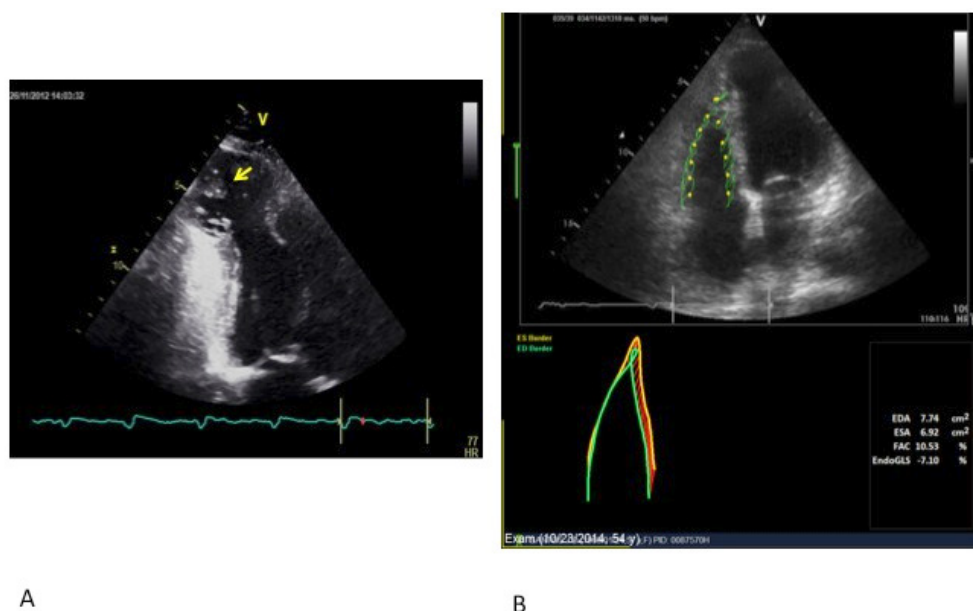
Chart A: Echocardiography of apical two-chamber view of the left ventricle shows an image suggestive of a large apical aneurysm filled with thrombus (yellow arrow). Chart B: Point Tracking Technique (Speckle tracking) supporting the analysis of RV systolic function in a patient with Chagas' disease. EDA: end-diastole area; ESA: end-systole area; FAC: Fractional area change; GLS-endo: Global longitudinal strain in the endocardial layer.
